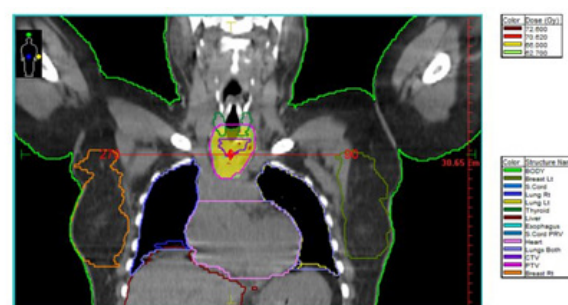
Shows a three dimensional reconstructed SAGITAL computed tomography scan of the chest, depicting the radiotherapy plan.
